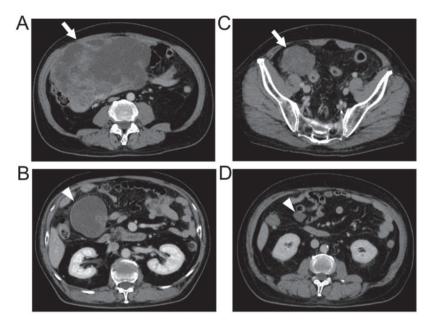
Coronal view of an abdominal computed tomography scan with contrast. (A and B) Prior to neoadjuvant therapy, a 22-cm tumor was identified in the right lower abdomen (A, arrow) and a 7-cm tumor was found to be located cranially to the main tumor (B, arrowhead). (C and D) Following neoadjuvant therapy, the primary and metastatic tumors shrank to 6.3 cm (C, arrow) and 1.9 cm (D, arrowhead), respectively.
